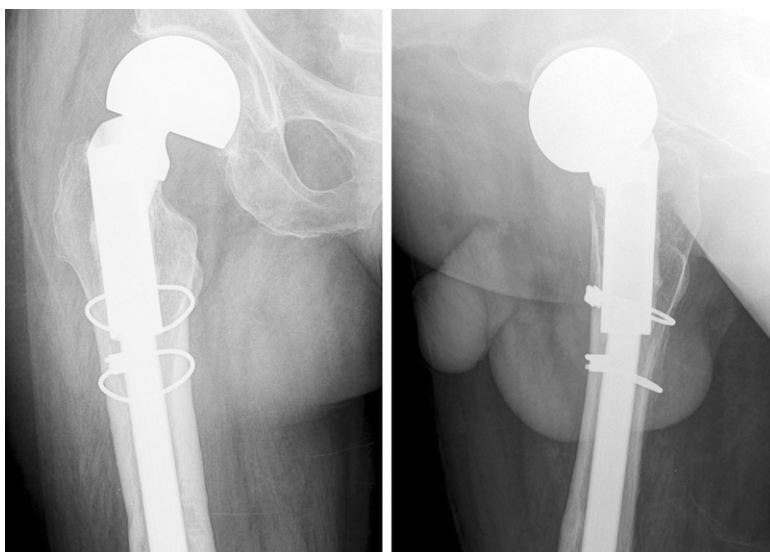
Radiographs made 2 years postoperatively, demonstrate no radiolucency and component position change.
